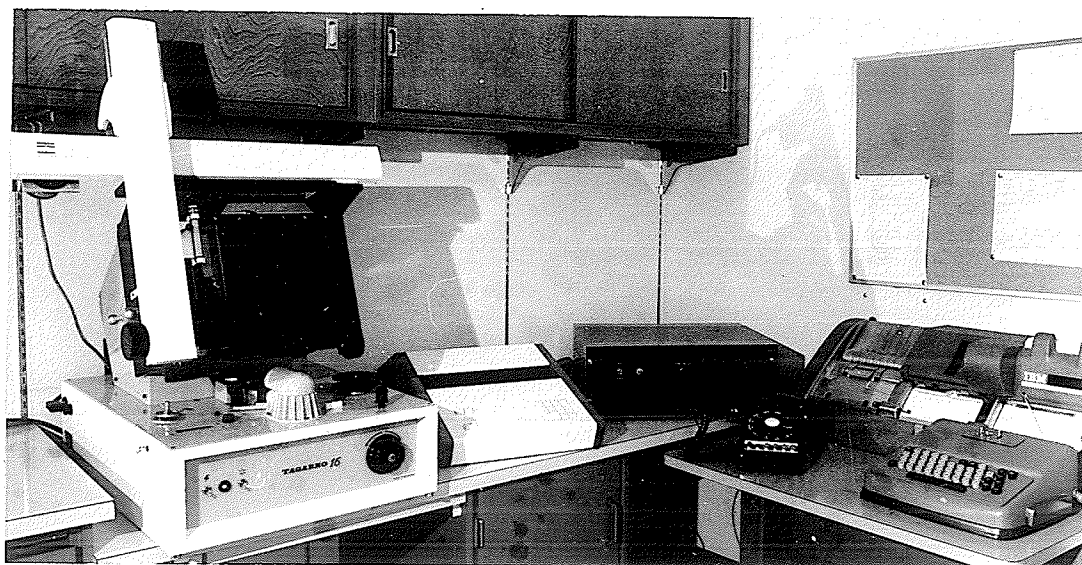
Digitizer used to record the co-ordinates of the landmarks from the P.A. cephalometric radiographs.
